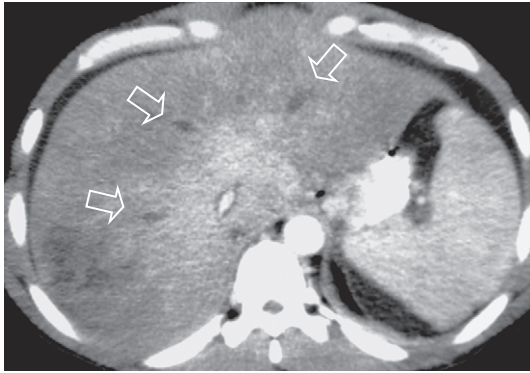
Contrast enhanced axial CT of the mid-liver. Note the uniform enhancement centrally in the caudate lobe, but peripherally the enhancement is decreased and irregular. The three hepatic veins (arrows) are unenhanced due to the fact that they are thrombosed.
